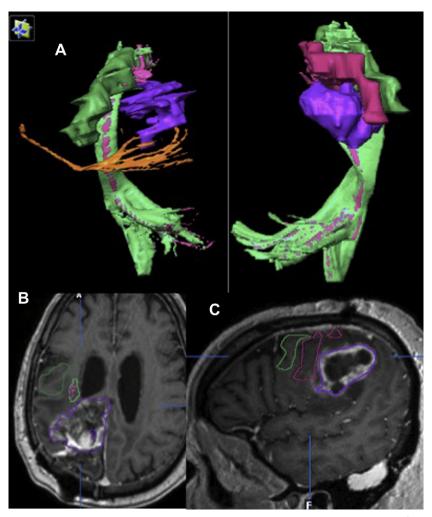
Fiber tracking superimposed to gadolinium-enhanced MRI to disclose the relationship of the tumor to the eloquent cortical and white matter areas. These areas are to be avoided in surgery and in radiosurgery planning. (A) Visualization of the relationship of the tumor with the cortex (magenta and green), with the projection of the cortical tracts also in green. It has disclosed 2 angles of visualization. (B) Axial view of the tumor in the right parietal area. (C) Sagittal view of the relationship of the tumor with the motor area. (B) and (C) are gadolinium-enhanced T1-weighted magnetic resonance images.
